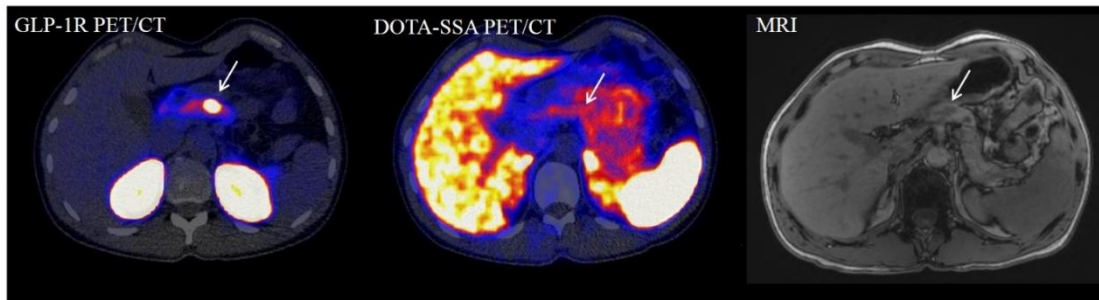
imaging produced by (from left to right) Exendin, DOTA-SSA-PET/CT and MRI (Boss *et al.*, 2019)
